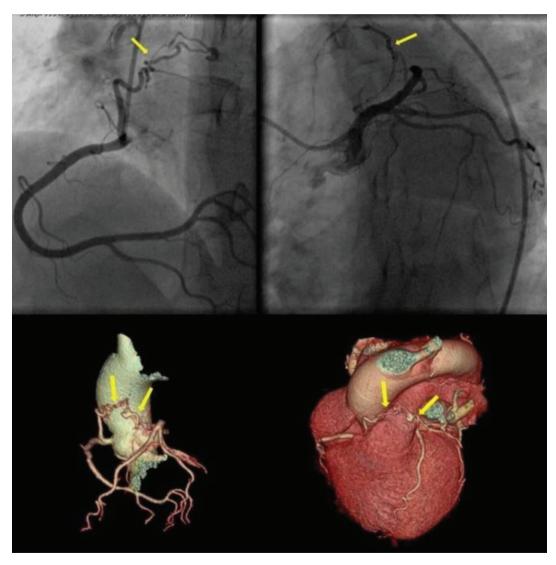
CAG and multislice CT images depicting the CAF between the first septal branch of the LAD artery and the PA; a second CAF between the conus branch of the RCA and the PA
